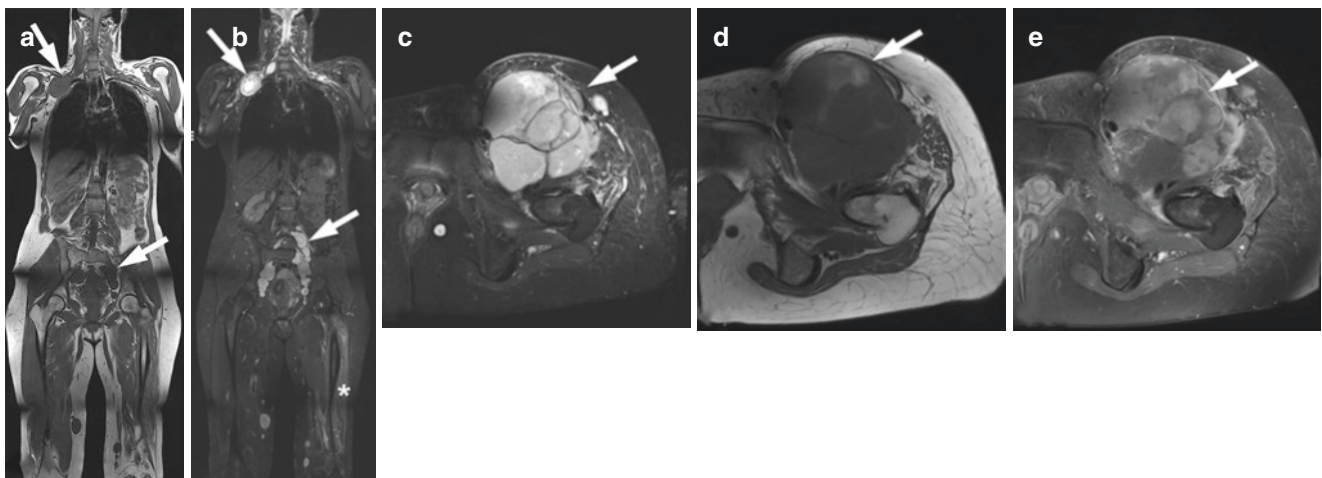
Middle-aged women with hereditary schwannomatosis. (a) Multiple tumours are seen on T1-weighted and (b) T2-weighted STIR images (arrows). Severe denervation oedema and atrophy of the left quadriceps muscle is present (asterisk in b) as a consequence of a large
